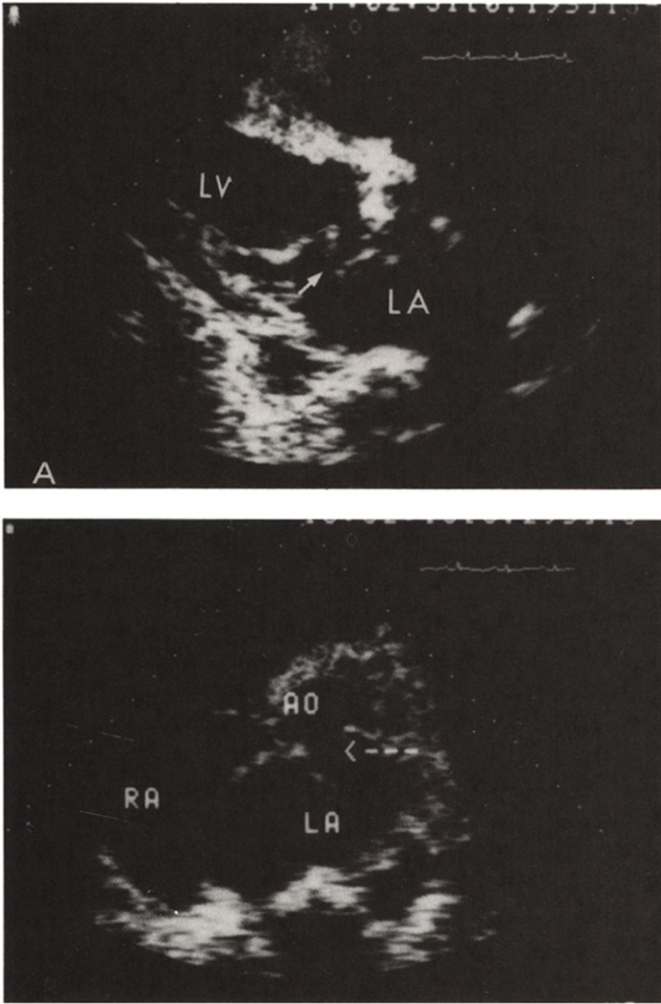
Two-dimensional echocardiography. A, Parasternal long-axis view. The arrow points to the ruptured abscess wall at the junction of the anterior leaflet of the mitral valve and aortic root. B, Short-axis view. Arrow points to the ruptured abscess at the left ventricular (LV) outflow tract which is in direct communication with the left atrium (LA). AO = aorta.
